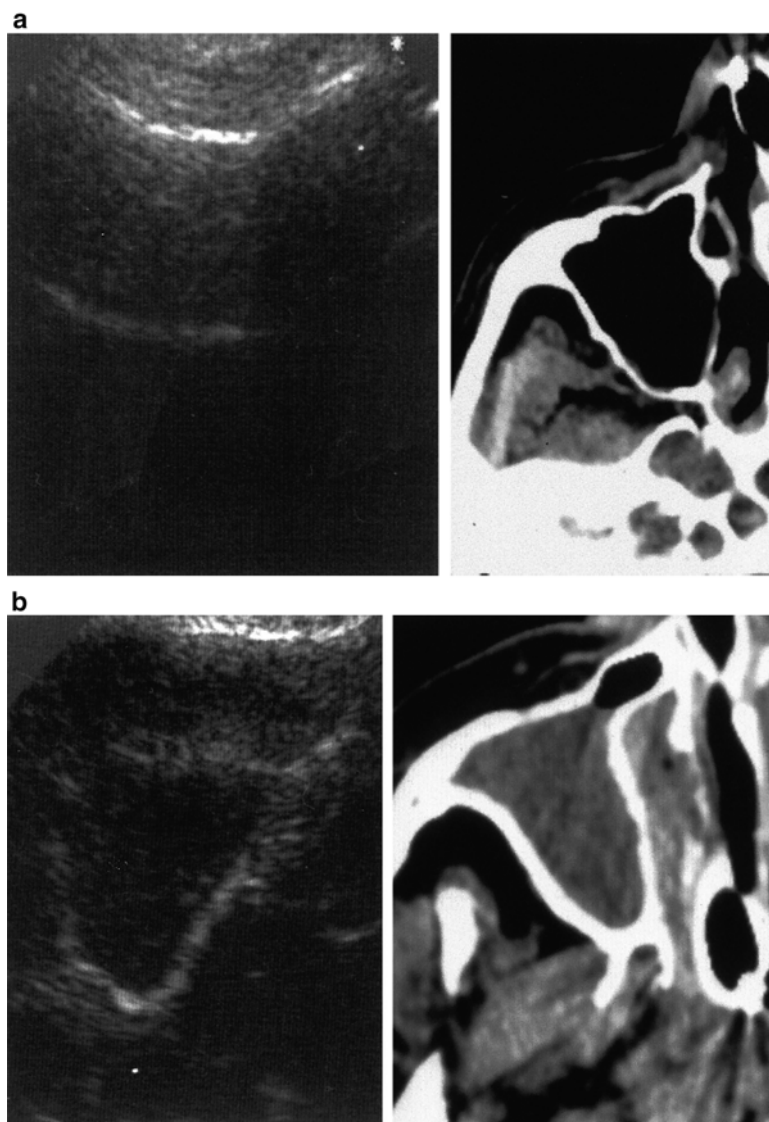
(a) Normal maxillary sinus. CT (*right panel*) and ultrasound equivalent (*left panel*) with complete acoustic barrier. (b) Radiological maxillary sinusitis with total opacity of the sinus (computed tomography) (*right panel*), compared with B-mode ultrasound visualization of the posterior and internal walls of the sinus (*left panel*) [194]. Reproduced with permission from Lippincott Williams and Williams
